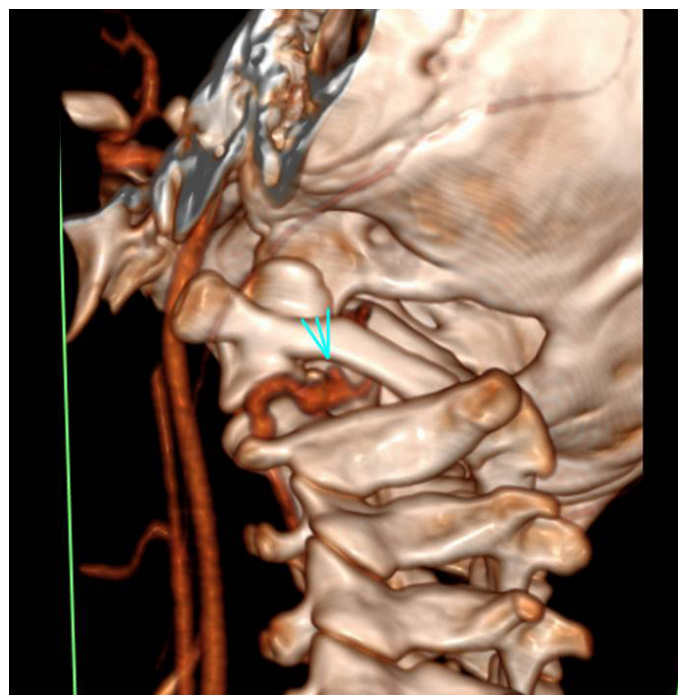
3D reconstruction of CT angiogram viewed from the left with cropping of skull base structures. The left vertebral artery does not pass normally between the skull base and C1. Instead, it is replaced by a persistent dominant first intersegmental artery. This is of an irregular calibre and has a pseudoaneurysm (arrow), which suggests trauma to the vessel presumably from being trapped between the left posterior arches of C1 and C2.
